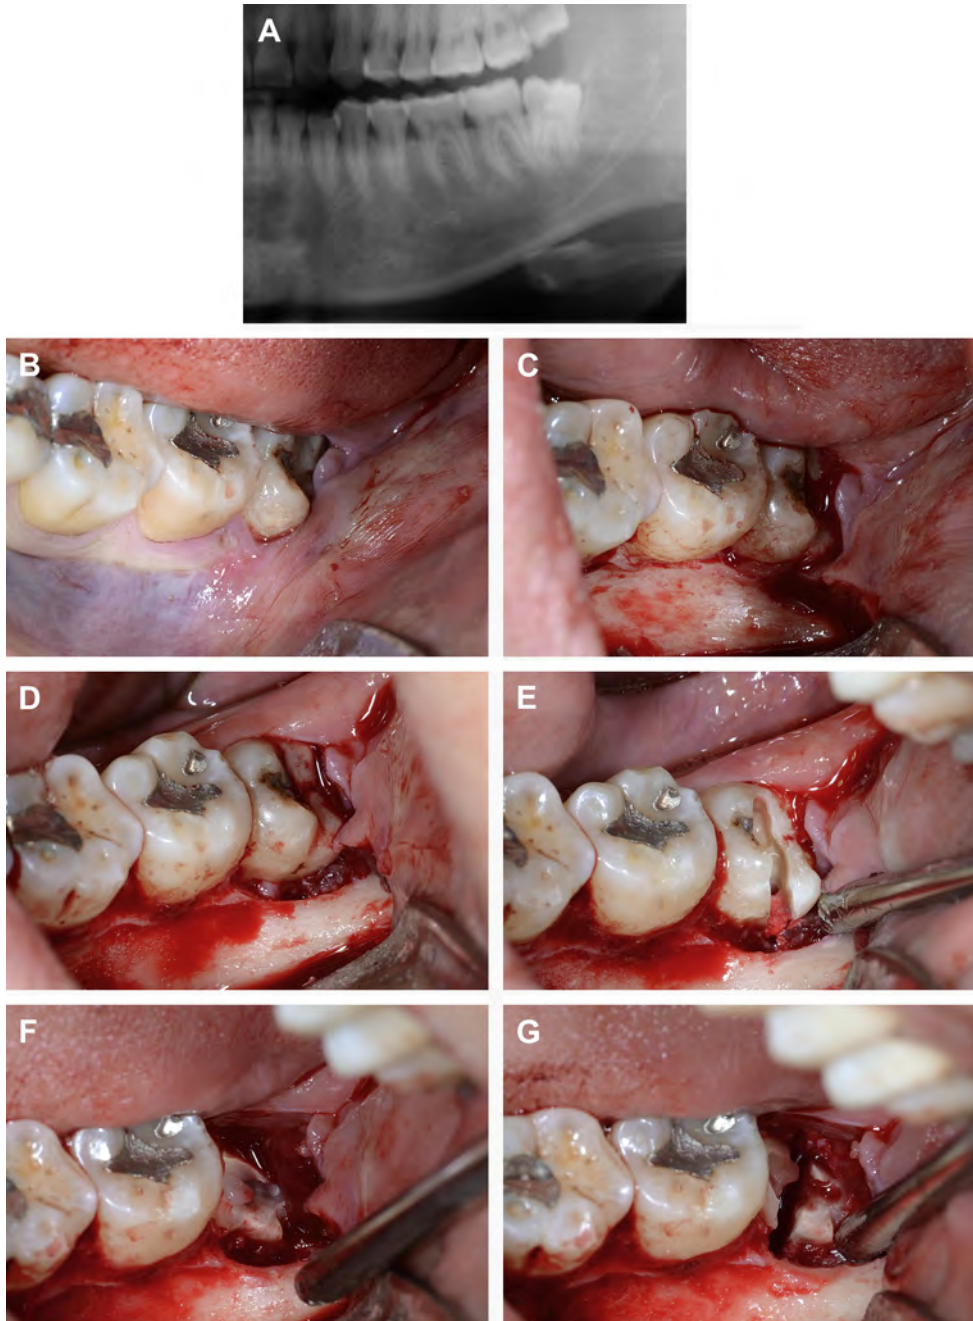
(A) Radiograph of distoangular impacted mandibular left third molar. (B) Surgical flap reflected. (C) Buccodistal bone trough. (D) Distal half of crown sectioned and removed. (E) Mesial half of crown removed after failed attempt to mobilize tooth. (F) Root structure visualized. (G) Roots of distoangular molar are sectioned, separated, and removed separately.
